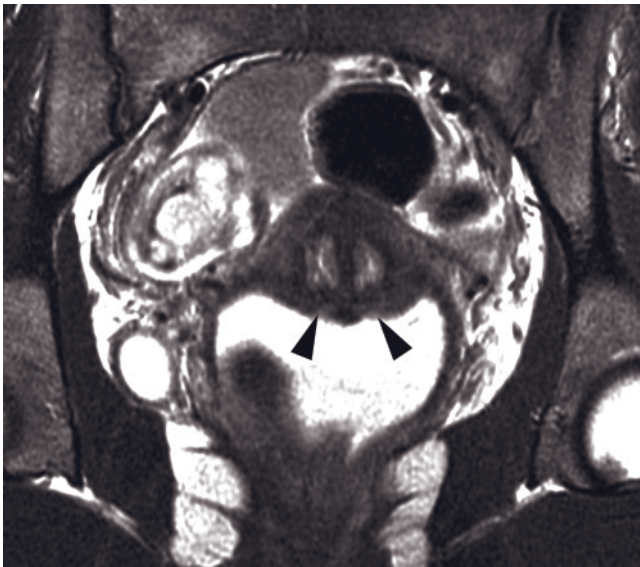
Bicornuate uterus. T2-weighted ETSE long-axis view of the uterus demonstrates widely divergent uterine horns and a concave fundus (arrow).
